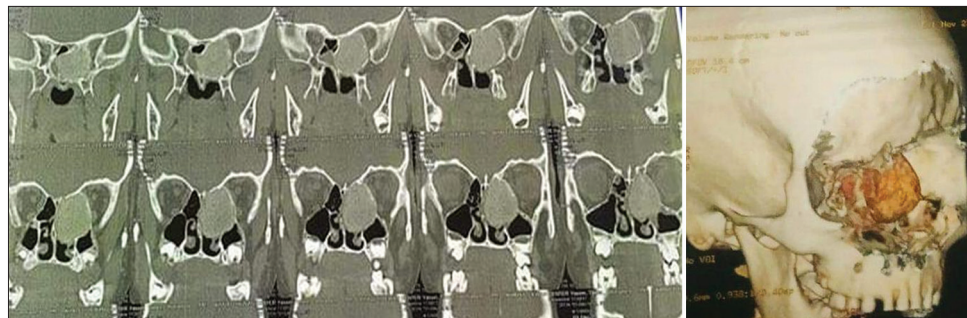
Coronal computed tomography scan and 3D reconstruction of the paranasal sinuses showing an expansile hyperdense lesion with a sclerosed peripheral mantle epicentered on the left sphenoid sinus and extending into the left nasal cavity.
